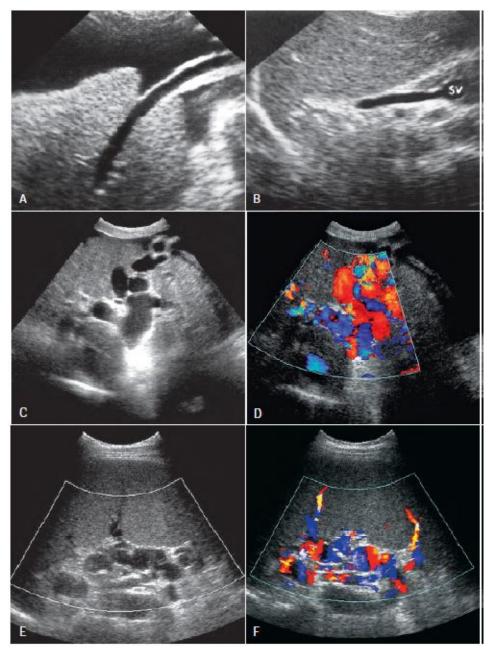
Portal hypertension.A, Sagittal image of recanalized paraumbilical vein in patient with gross ascites. B, Sagittalimage shows enlarged coronary vein running cephalad from the splenic vein *(SV)*. C, Gray-scale image, and D, color Doppler image, showextensive varices in the distribution of the coronary vein. E, Gray-scale image, and F, color Doppler image, show splenic hilar varices.
